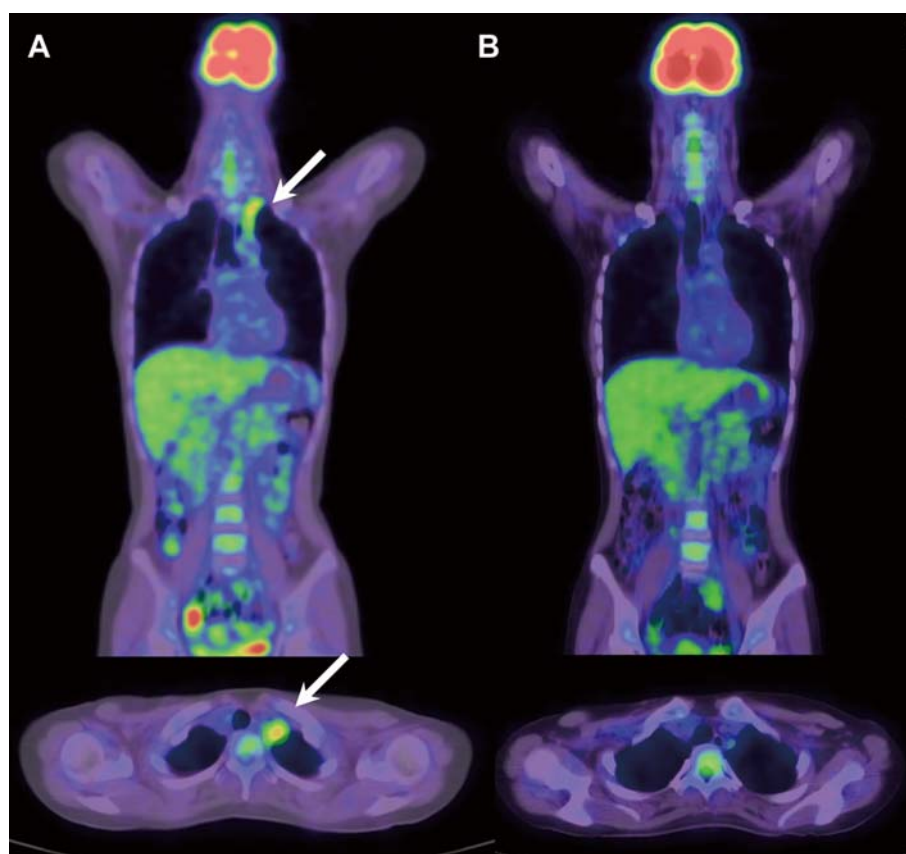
PET/CT fused images of a young female patient with Takayasu arteritis.
